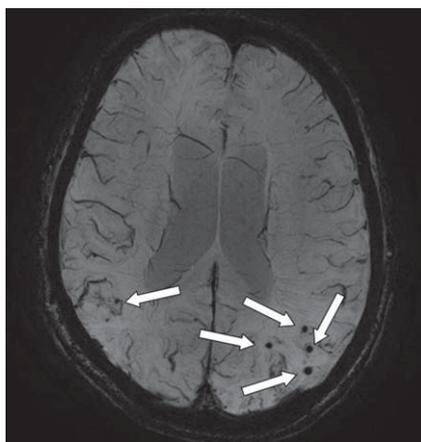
An axial MRI image of a susceptibility weighted image (SWI) that provides information on the presence of microbleeds (arrows; occipital part of the cortex). This is an image of a 68-year-old male with a diagnosis of Alzheimer's disease. On presentation, he had an MMSE of 23. On MRI, there was evidence of moderate atrophy of the medial temporal lobe, mild global cortical atrophy, beginning confluent white matter hyperintensities and multiple microbleeds (mostly with a lobar location).
